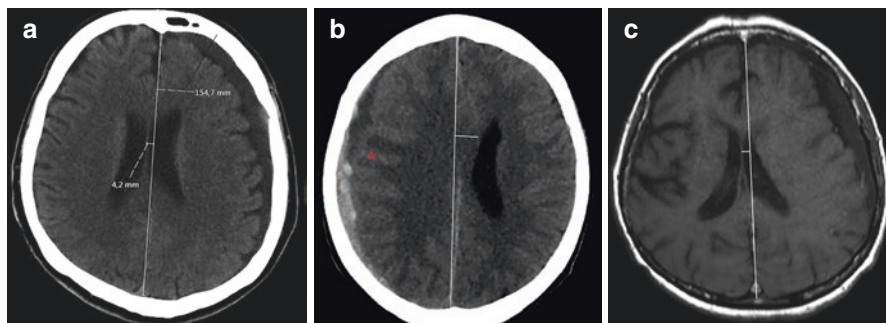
Cases of midline shift secondary to the mass effect are observed on CT (a) and MRI (c) with chronic subdural hemorrhage and CT (b) images with chronic acute bleeding from different patients. On axial CT, a line is drawn between the most protruding areas of the frontal and occipital bone (midline line). The distance between this line and the septum pellucidum shows the degree of shift from the midline. Red asterisk (b) shows effacement in the cerebral sulcus due to the mass effect
